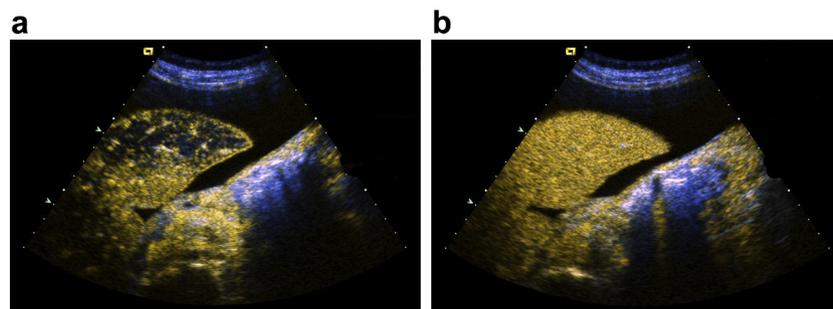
Contrast-enhanced ultrasound examination images of atelectasis with early pneumonic infiltration. The homogeneous contrast enhancement rules out abscess formation. The enhancement patterns in the early (a) and late (b) arterial phases are indicated.
